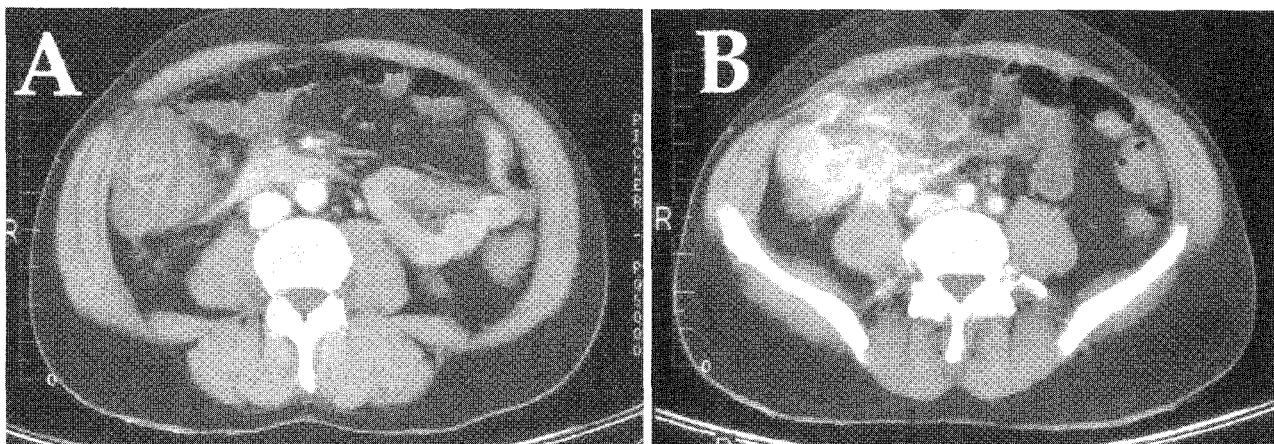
Computed tomography of the abdomen showing thickening of the right colon wall (Fig. 1A) and an inflammatory mass of ileocaecal junction, compatible with the diagnosis of complicated inflammatory bowel disease (Fig. 1B).
